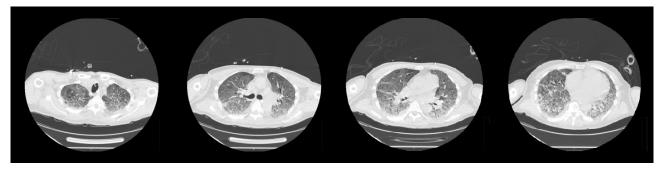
Repeat computed tomography scan of the patient's lungs shows progressive worsening of pulmonary changes, both in intensity and extent, now diffuse in nature. Evidence of pulmonary artery thromboembolism is seen in multiple branches of the pulmonary arteries.
